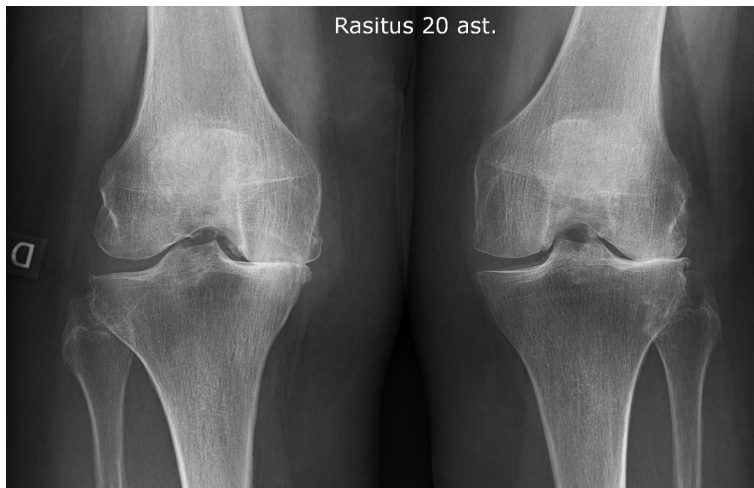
Radiograph showing OA of the knee.
